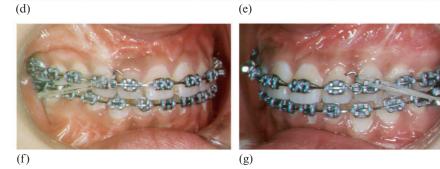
Case 2: (a) pre-treatment postoanterior skull radiograph; (b) pre-treatment lateral cephalogram
